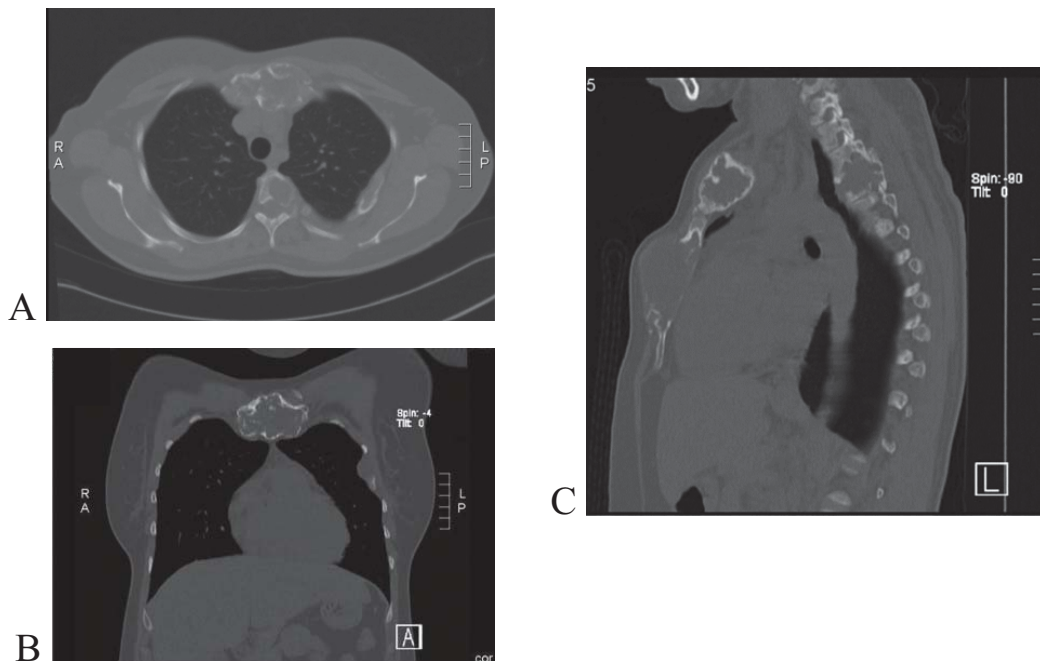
A) CT scan of the chest cross section showing involvement of the sternum and 4th vertebral body; B) MRI coronal view showing the multi septated hyper translucent sternum; C) MRI sagittal view showing the sternal and 4th vertebral body destruction.
